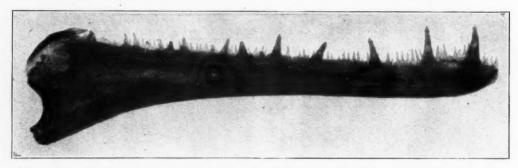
Radiograph of half of mandible of gar-pike.
